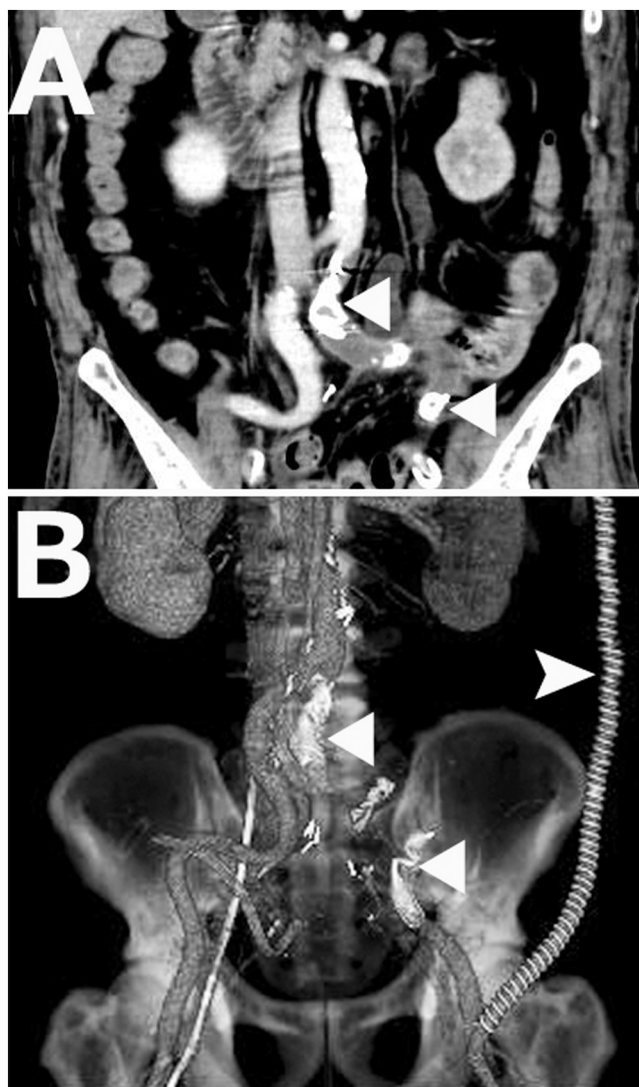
A: Computed tomography image after the 4th operation demonstrates disappearance of the blood flow between the left common iliac artery and the external iliac artery following the use of plugs (white triangles), and thrombus formation can be visualized in the vessel between these 2 arteries. B: Three-dimensional (3-D) computed tomography image demonstrates good patency of the axillofemoral artery bypass (white arrowhead).
